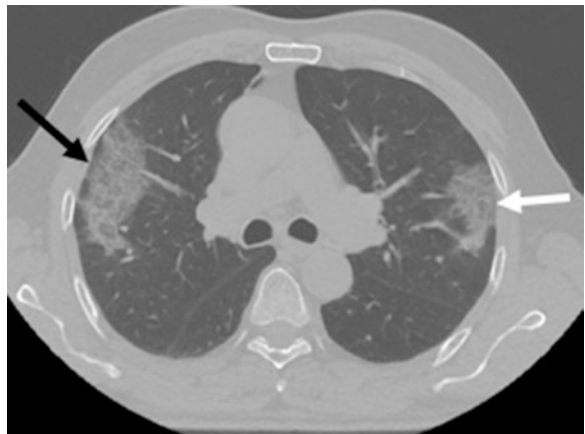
Axial chest CT. A peripheral crazy-paving opacity in the right lung (black arrow) and a subpleural crazy-paving opacity in the left lung (white arrow). In crazy-paving opacities, the density of lesions is increased; however, there is associated interlobular septal thickening and enlarged intralobular lines
